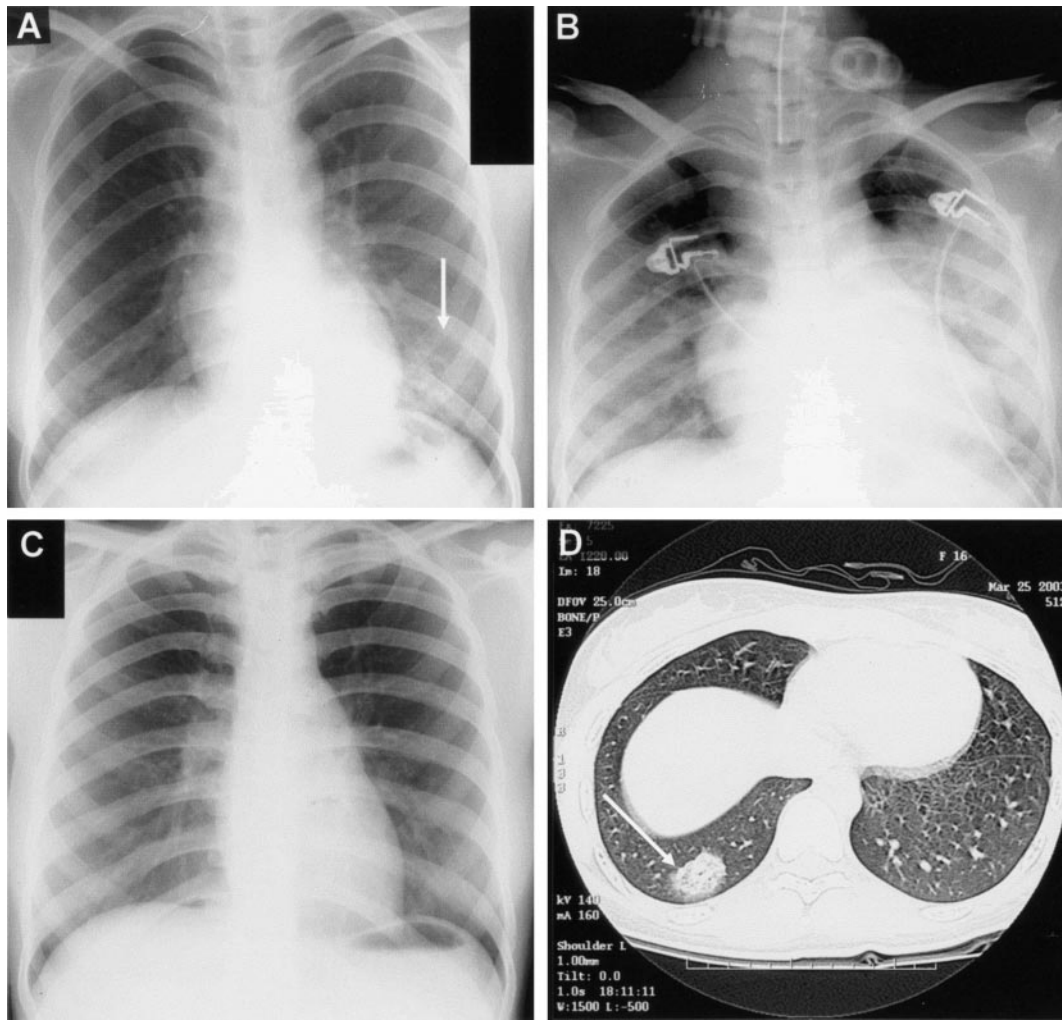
CXRs and HRCT scans of the thorax for 2 children with SARS. A, Admission CXR for a 15-year-old girl, showing left lower lobe consolidation 3 days after the onset of fever. B, Progressive radiographic deterioration, resulting in widespread bilateral consolidation at the time of intubation and mechanical ventilation for the same patient, 12 days after the onset of fever. C, Normal CXR findings for a 16-year-old girl obtained at admission, 2 days after the onset of fever. D, HRCT scan of the thorax for the same patient, showing peripheral, subpleural, focal consolidation in the right lower lobe that was not evident on CXRs.
